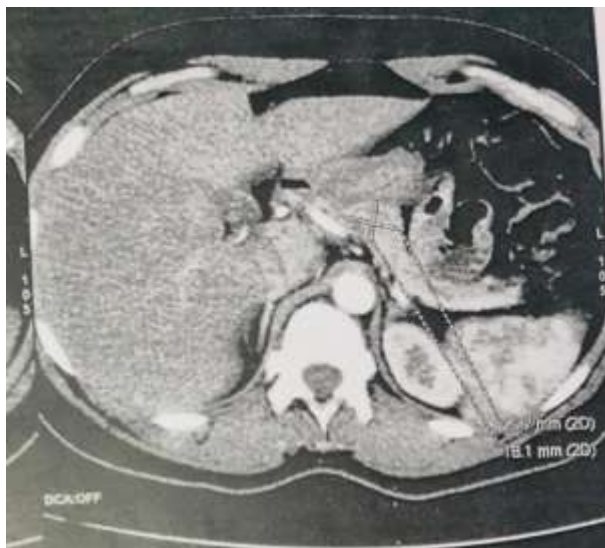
CT scan showing an isthmic pancreatic tumor.
